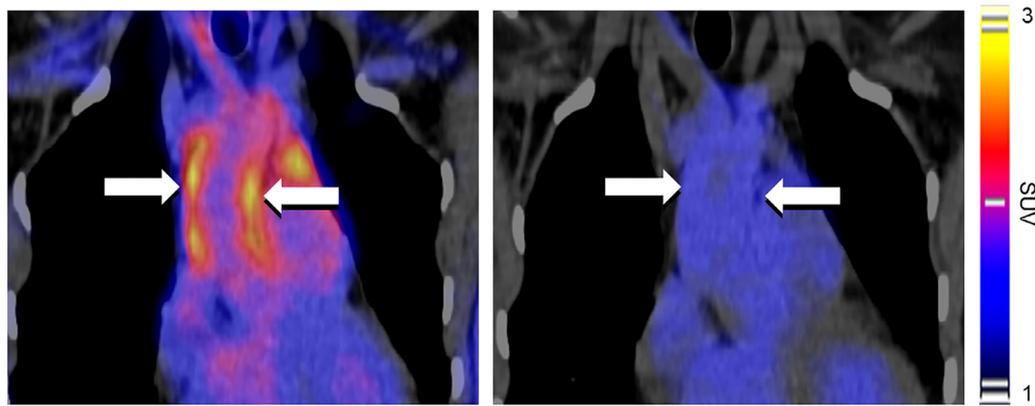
Fused FDG-PET/CT coronal images (left) of the patient with Takayasu arteritis presented in Fig. 3 demonstrate increased FDG uptake in the aortic wall (arrows), compatible with aortitis. A follow up study (right) performed 10 months later after corticosteroid therapy shows complete resolution of the inflammation (arrows).
